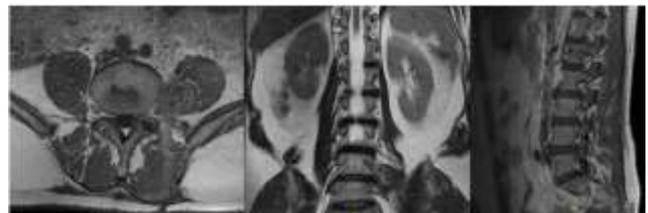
Postoperative MRI of Case two. Image A: axial scan. Image B: sagittal scan. Image C: coronal scan.
